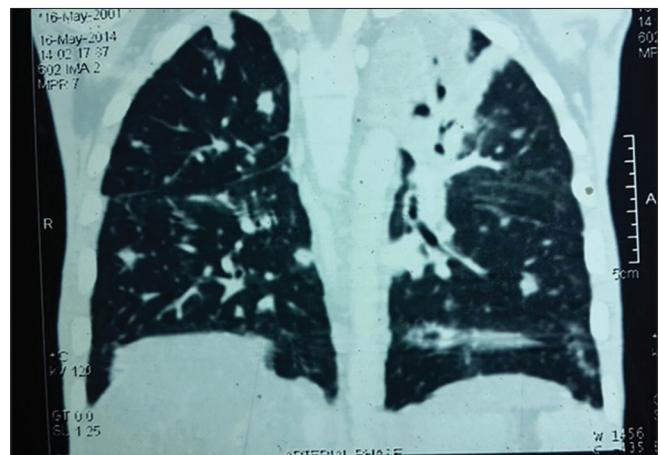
A Contrast-Enhanced Computed Tomography (CECT) Thorax 13-year-old girl with suspected Disseminated Tuberculosis showing enlarged multiple lymph nodes probably of Tubercloid origin
